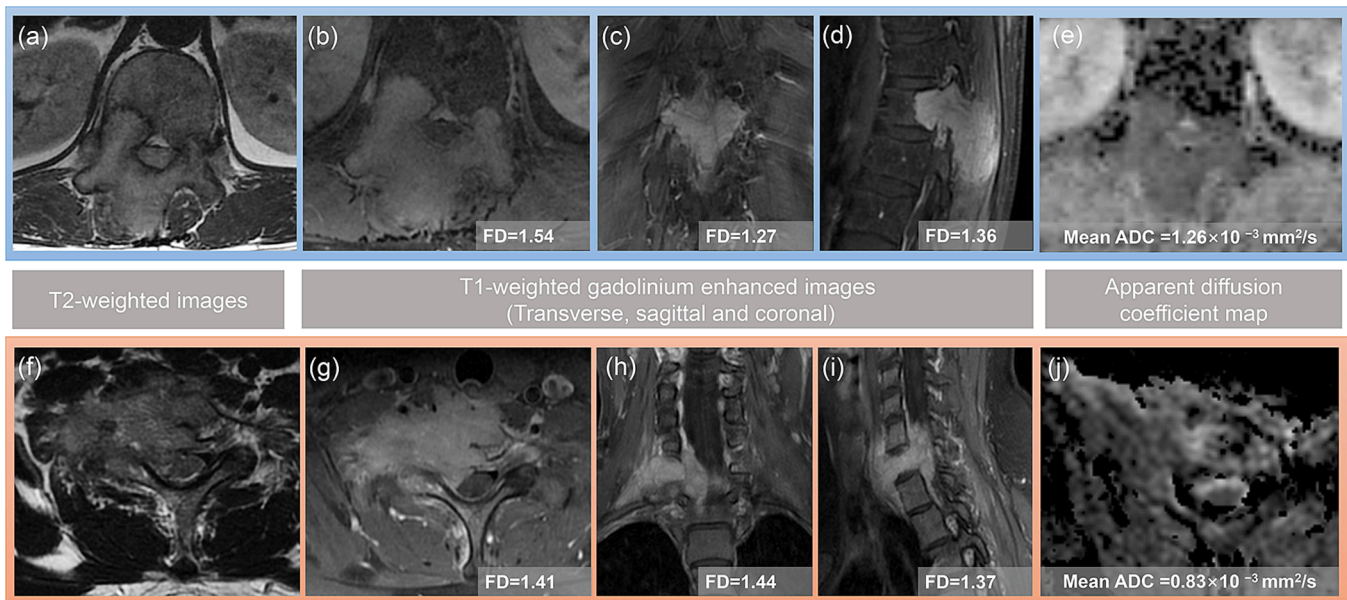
MRI images of two cases with pathologically confirmed giant cell tumor of bone. (a-e) A 29-year-old male, no recurrence was found at 30 months follow-up; (f-j) A 23-year-old male, tumor recurrence was confirmed 5 months after surgery. The FD and mean ADC of the shown layer are listed. Compared to FD, ADC values showed a more noticeable decrease. FD, fractal dimension; ADC, apparent diffusion coefficient.
